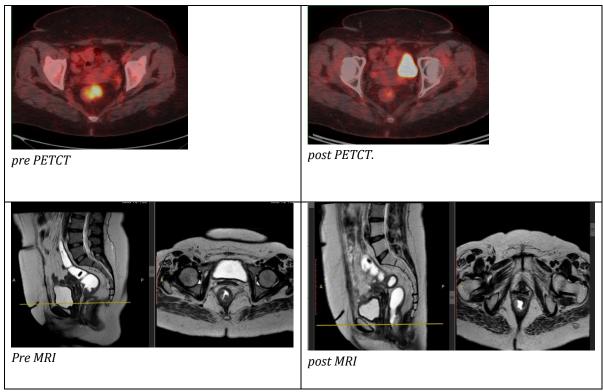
44 years old female Patient with LARC confirmed by PET/CT and MRI. Post NAT, PET/CT and MRI showed CMR and CR using PERCIST and RECIST criteria respectively. Post operative pathology revealed complete pathological response
